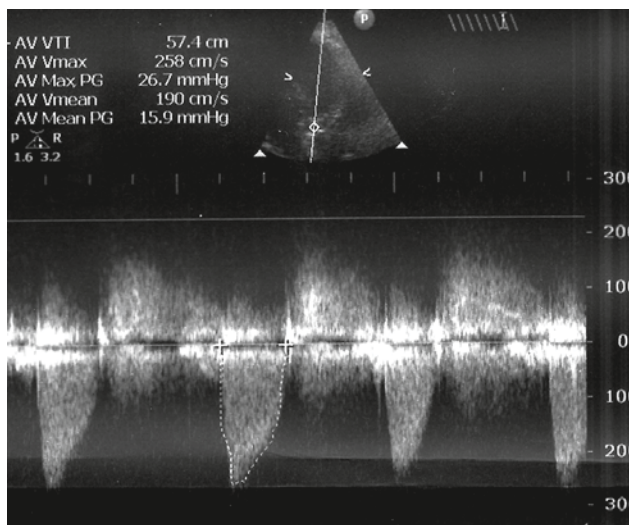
Transthoracic echocardiogram, continuous wave Doppler – gradient through the decalcified aortic valve, below 30 mm Hg
